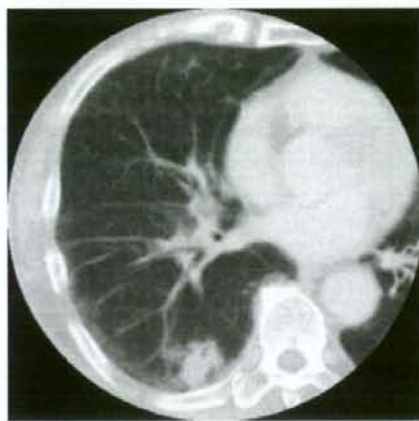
Computed tomography (CT) scan before biopsy revealing a nodular opacity, 2 cm in diameter, in the posterior basal segment of the right lower lobe
